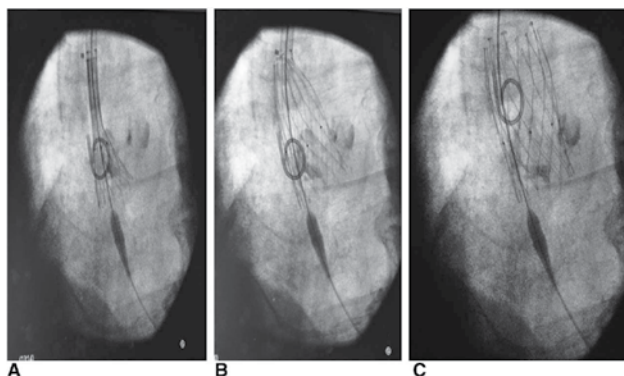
Delivery of the aortic valve under X-ray control. Once the material was delivered, the self-expanding aortic valve took its original form (A–C).
